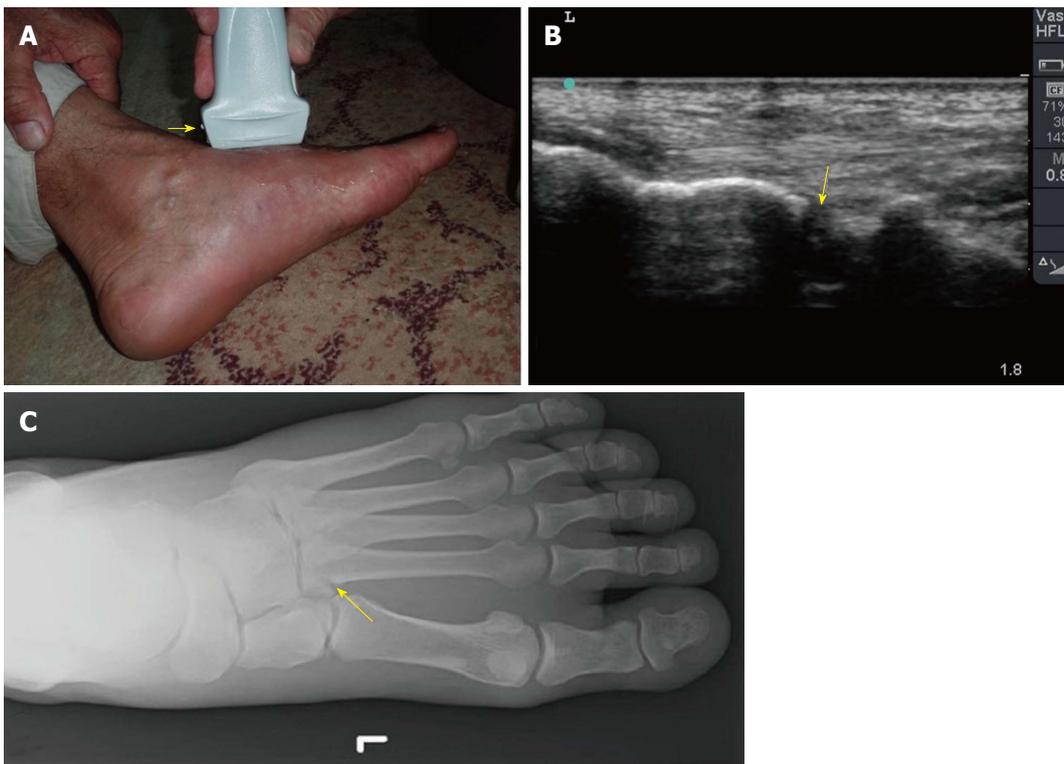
Point-of-care ultrasound of a 60-year-old man who twisted his left ankle and could not walk on it. He had swelling of the left foot with maximum tenderness on the base of second metatarsal bone (A). The yellow arrow indicates the marker of linear probe which is shown on the left side of the screen while the groove on the other side is shown on the right side of the screen. B mode images of the previous patient showed a cortical defect (yellow arrow) at the base of the second metatarsal bone suggestive of a fracture (B). Plain X-ray of the foot confirmed these findings (C). Ultrasound study was performed by Professor Fikri Abu-Zidan, Department of Surgery, Al-Ain Hospital, Al-Ain, UAE.
